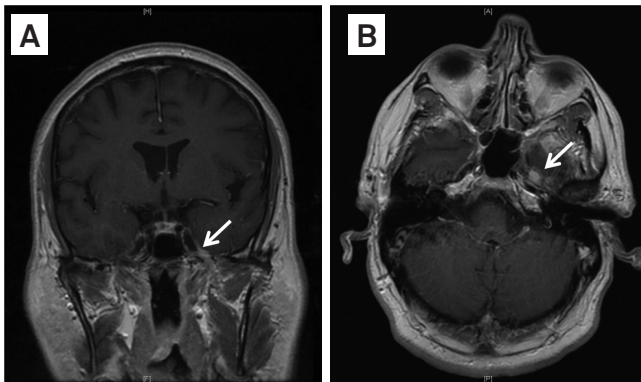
Magnetic resonance imaging of the brain (T1W) with gadolinium, coronal (A), and axial (B) shows an asymmetrically enlarged enhancing mandibular branch of the left trigeminal nerve at the level of the foramen ovale and masticatory space (arrow). There was no bony erosion on the computed tomography scan (not shown).
